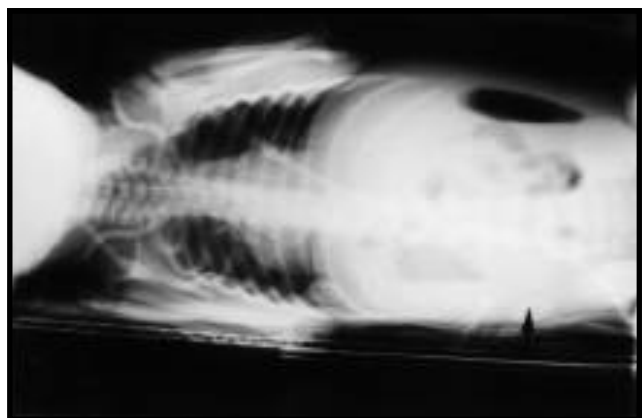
Right decubitus x-ray of the abdomen showing free gas in the peritonium.
